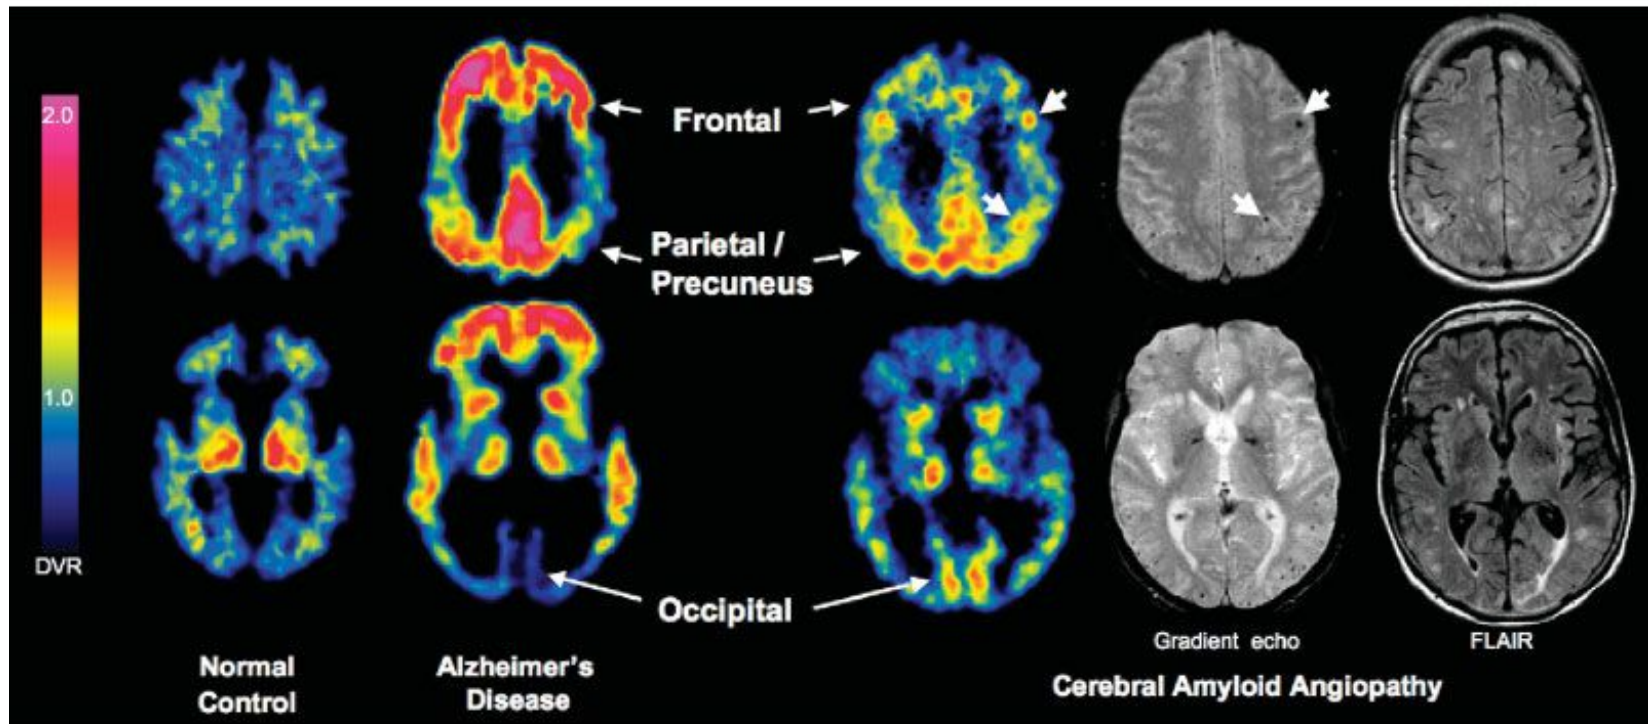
Representative Pittsburgh Compound B (PiB)-positron emission tomographic (PET) images at two transaxial levels from normal control (NC) (PiB-negative), Alzheimer's disease (AD), and cerebral amyloid angiopathy (CAA; Subject 4; see Table 2) subjects. Compared with AD and NC, CAA subjects had an intermediate level of global PiB retention (shown quantitatively in Fig 2), but compared with AD, had relatively increased occipital retention (see Fig 3). Microbleeds seen in this patient, shown in coregistered gradient echo magnetic resonance images, at times appear proximal to foci of amyloid deposition (small arrows).
